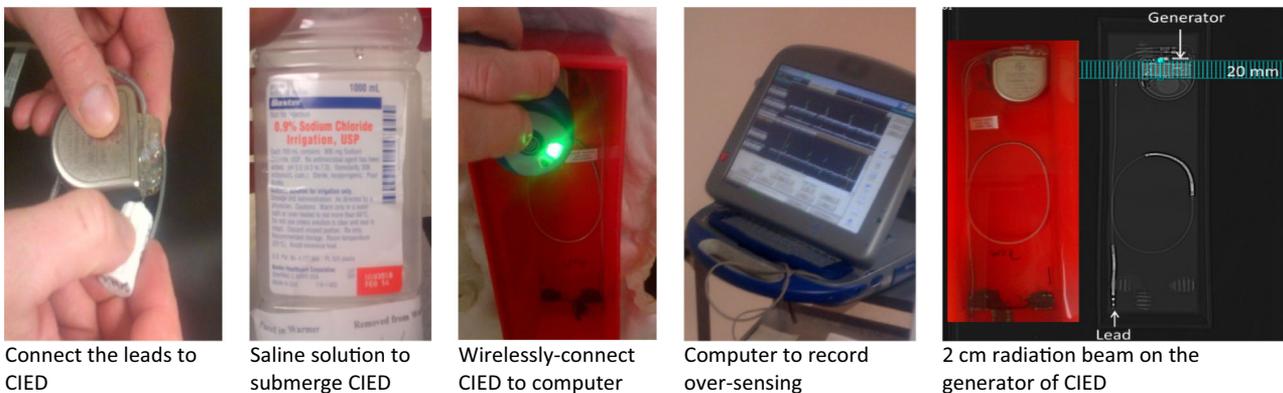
The steps of setting up a CIED for cine CT scan at the dose rates of 0.9 to 41.2 mGy/s in 8 steps of 10, 20, 30, 40, 50, 110, 220, and 440 mAs.
